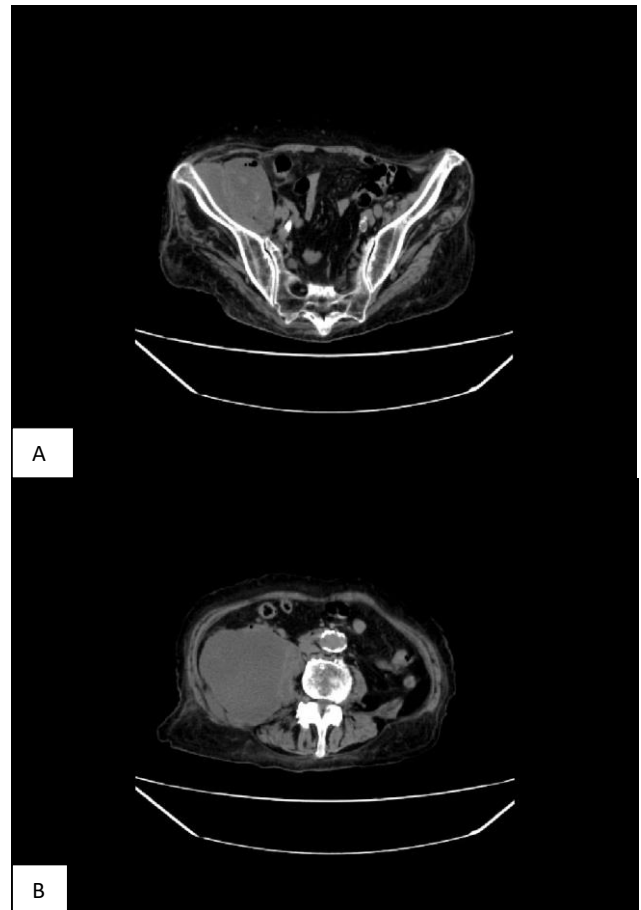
(A and B): CT scan of pelvis and abdomen cavity, shows right side M. iliopsoas abscess in the right side, about 10-12 cm in size.
